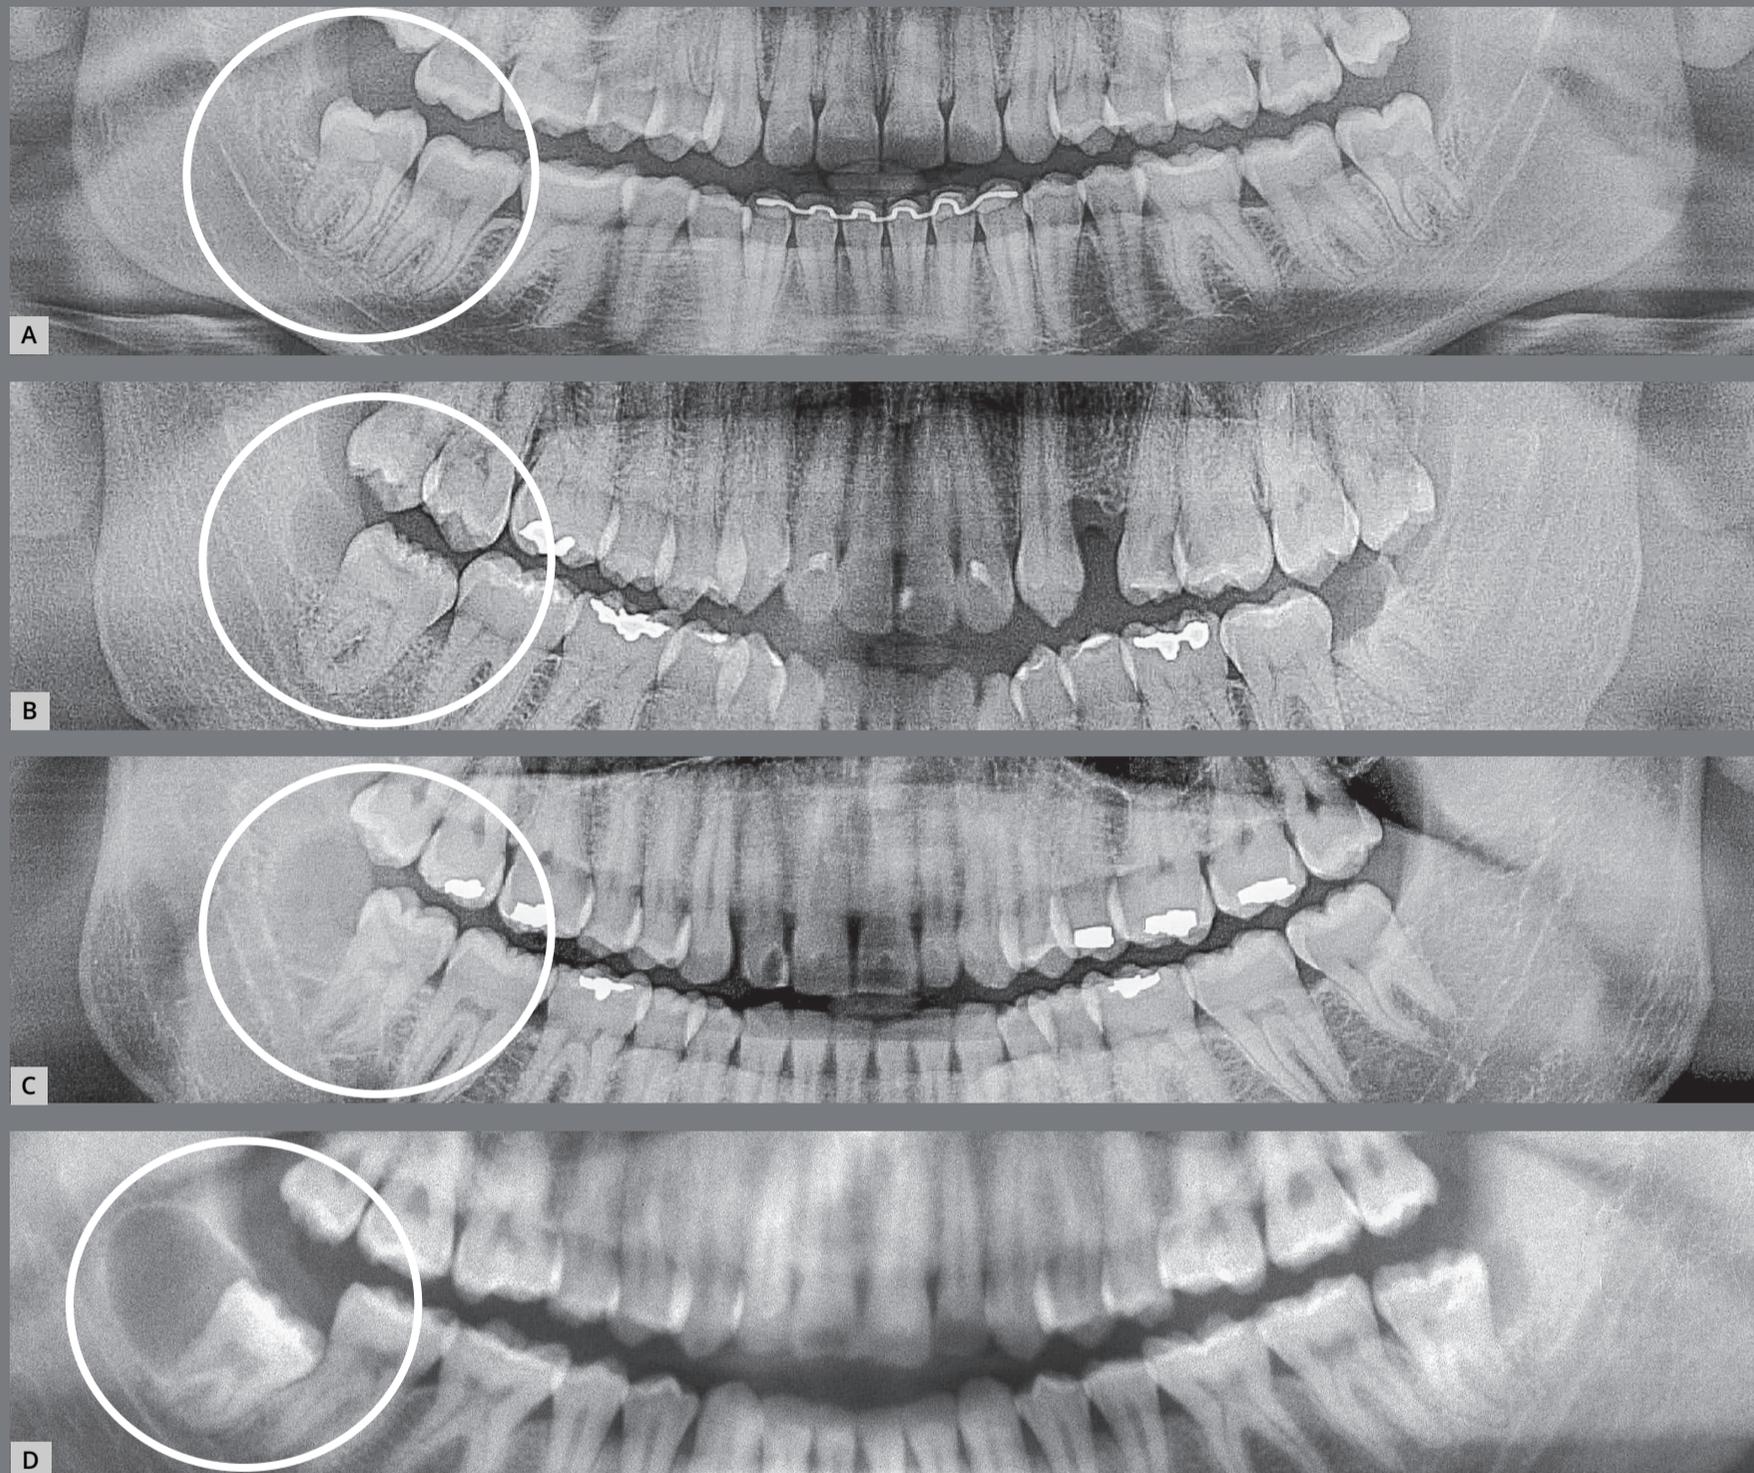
Paradental cysts from incipient development up to advanced occurrence on the distal surface of partially erupted lower third molars on the right side of panoramic radiographs. It is noteworthy that the patient in A was discharged from orthodontic treatment.
